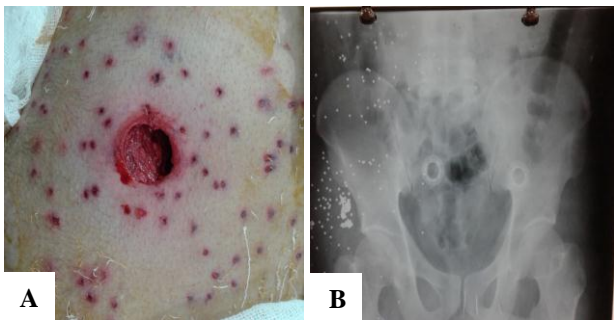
(A) showing lacerated wound around gluteal region, (B) X-ray of the same patient.
